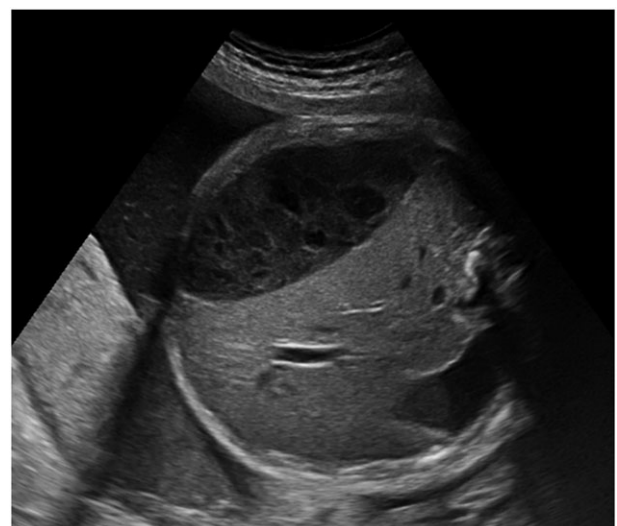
Case #12, 35 weeks of gestation. Prenatal midgut volvulus: Ultrasound features: wide meconium pseudo cyst (axial ultrasound image)
